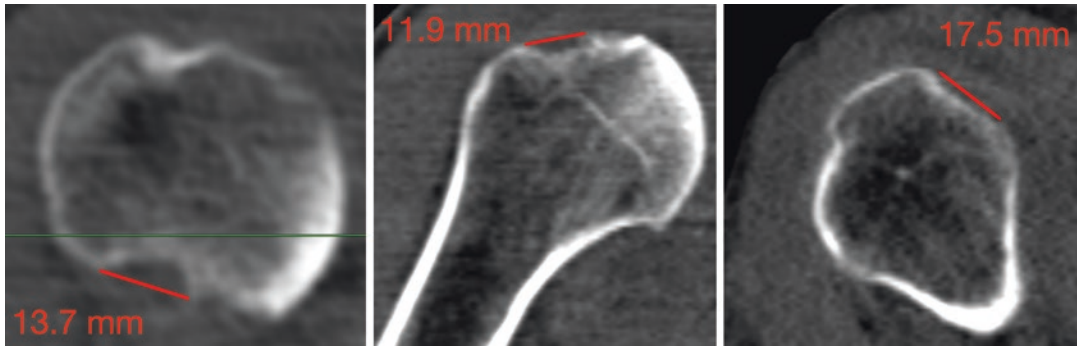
Edge-to-edge measurement of a Hill-Sachs lesion on axial, coronal, and sagittal CT images
